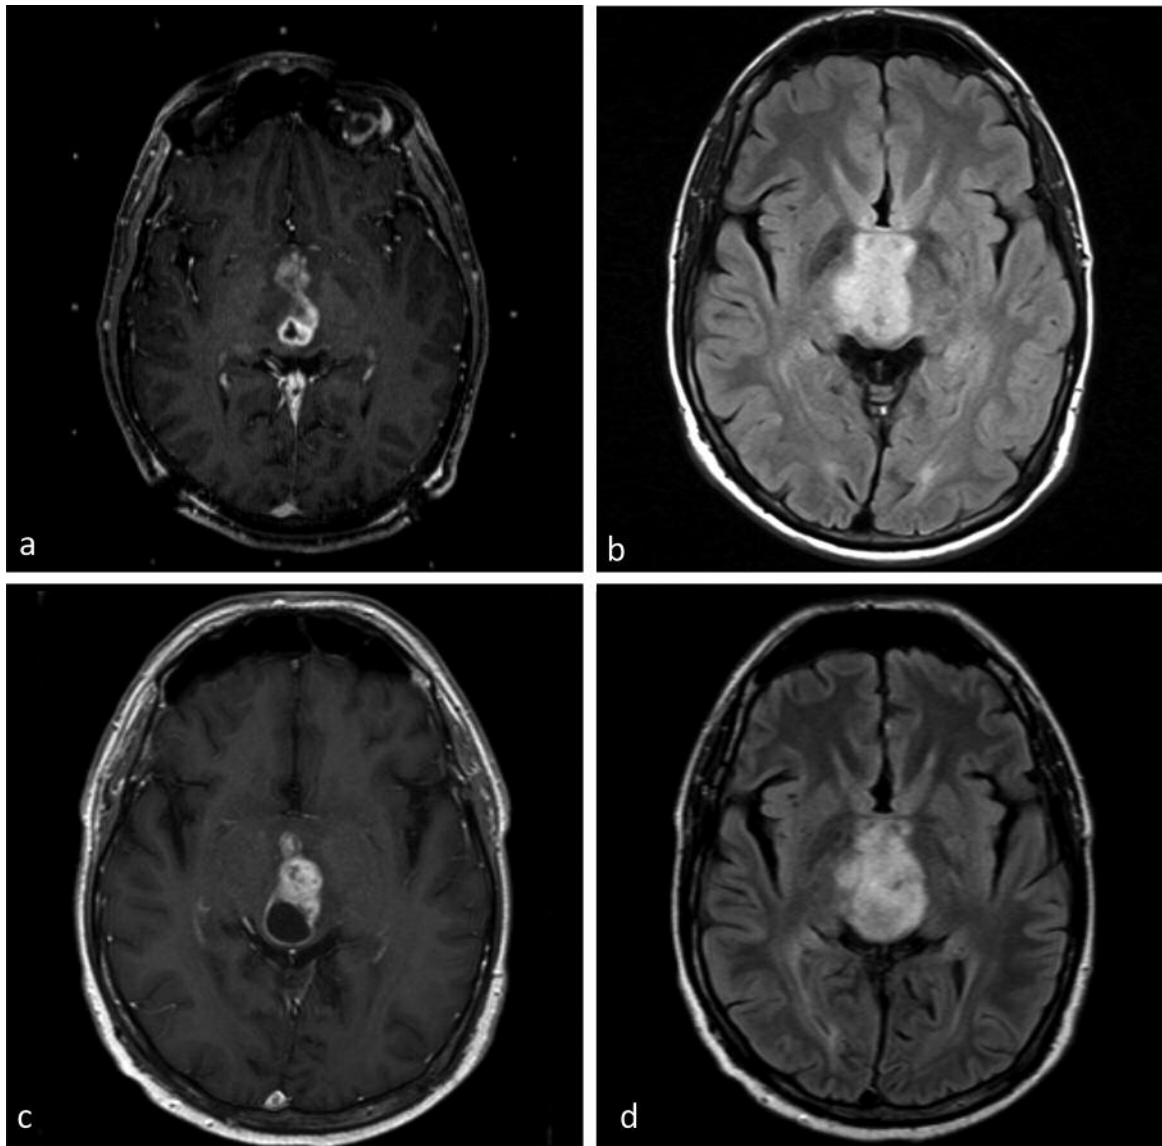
Brain MRI before and after treatment. A: Three months pre-treatment axial T1 post-contrast. B: Three months pre-treatment axial Flair. C: 5 months after treatment initiation axial T1 post-contrast. D: Five months after treatment initiation axial Flair.
